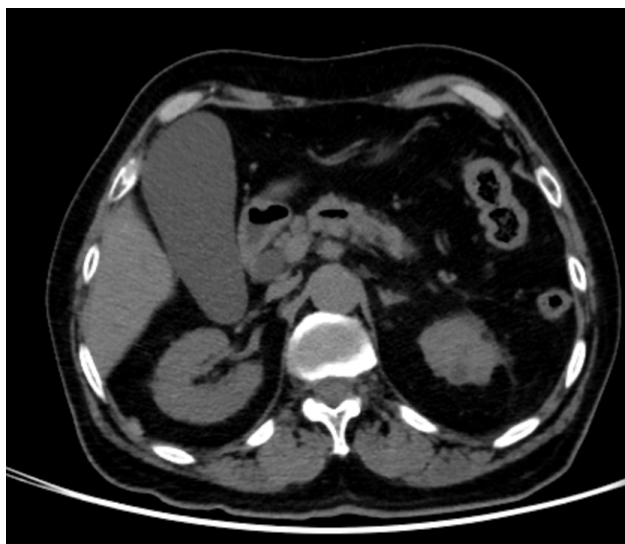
Acalculous acute cholecystitis. A 79-year-old male patient was admitted to the emergency department with the right upper quadrant pain. Contrast-enhanced computed tomography shows hydrops in the gallbladder and an increase in the gallbladder wall thickness (arrows). A single session percutaneous gallbladder aspiration was performed. Two days later, the patient was discharged
